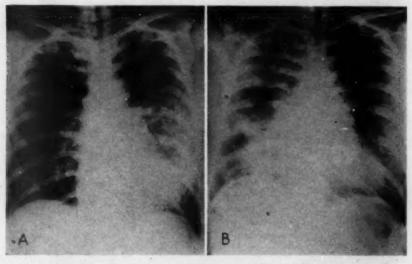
(case 5).—A, roentgenogram taken three days after admission, showing nodular and confluent densities in the left lung field and softer densities extending down and out from the right hilus.
